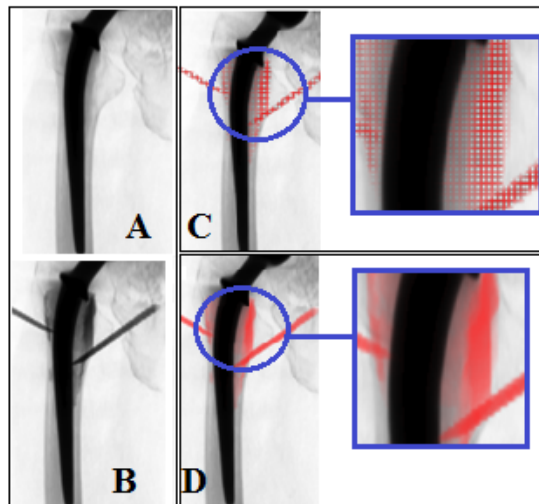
Difference Images Tool. (A) – Radiograph captured before the operation. (B) – Radiograph after the needle and cement target insertion. (C) – Deformed Annotation Grid for the difference image between (A) and (B). (D) – (Flickering) Overlaid difference image between (A) and (B).
